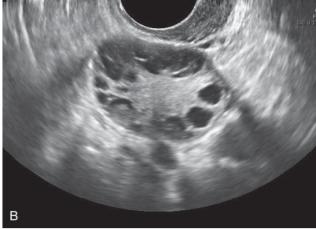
(A) Corpus luteum cyst. (B) Transvaginal ultrasound showing polycystic ovary.
